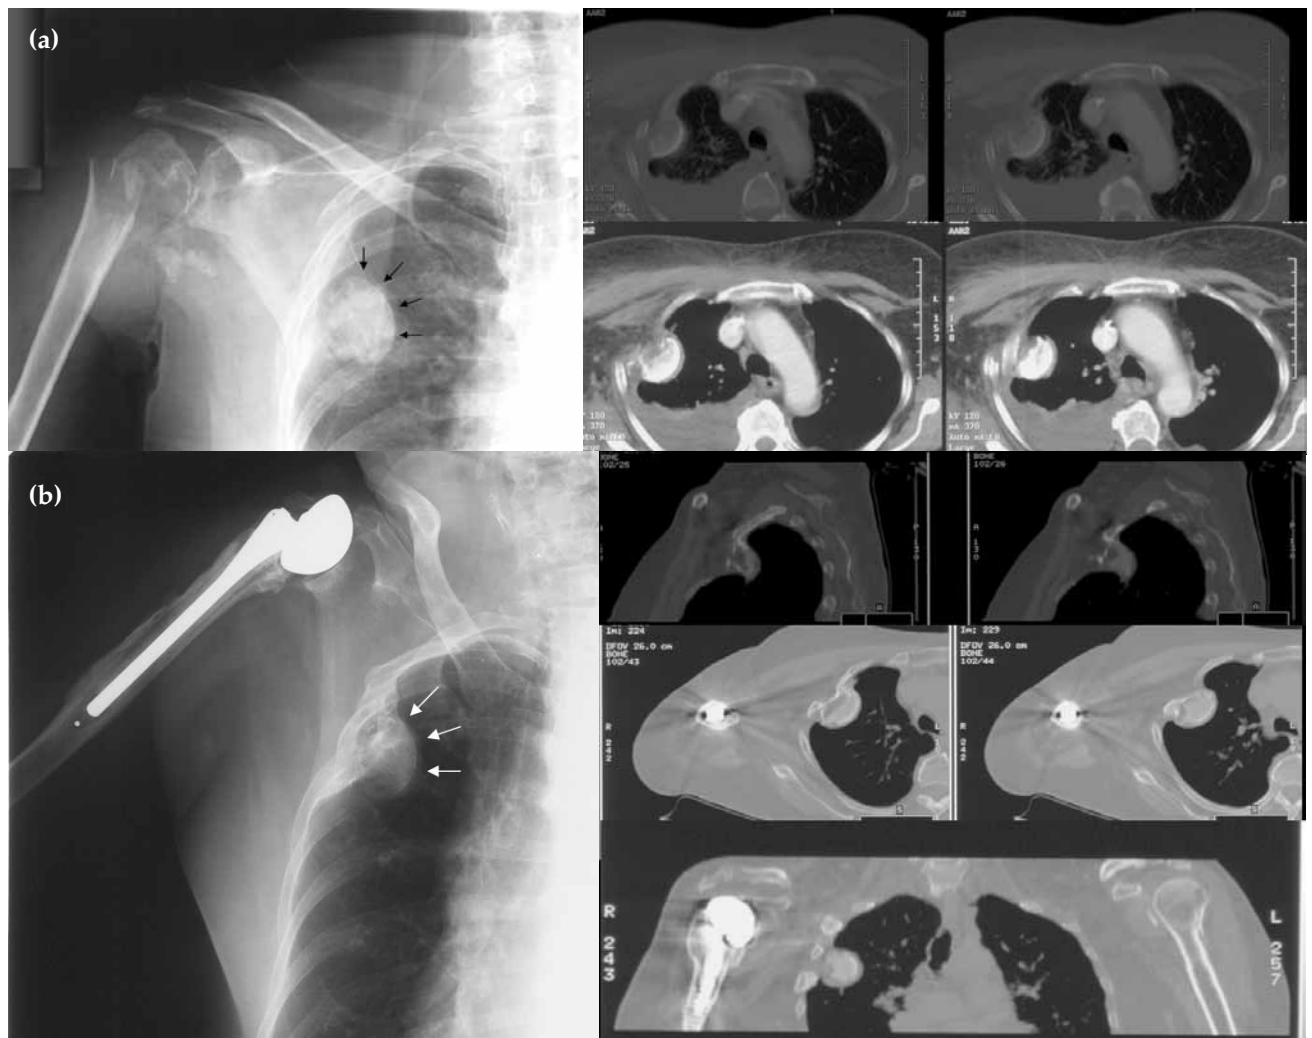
Figure Radiography and computed tomography of the chest showing (a) a proximal humerus fracture, displacement of the humeral head into the right lung field (arrows), and a moderate haemothorax. (b) At 27-month follow-up, there is no change in size or location of the intrathoracic humeral head (arrows) since initial imaging and no evidence of pulmonary complications.
